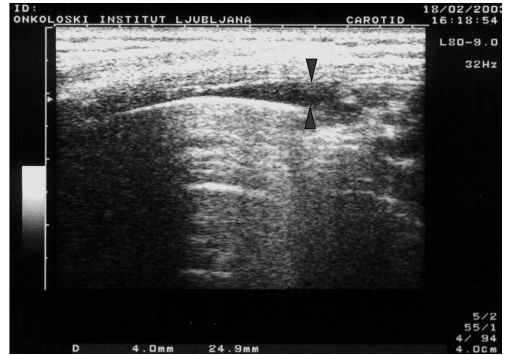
Sonographic examination of the left pleural space in decubitus position. Three minutes later typically wedge-shaped 4 mm thick fluid layer was observed (between arrowheads)
